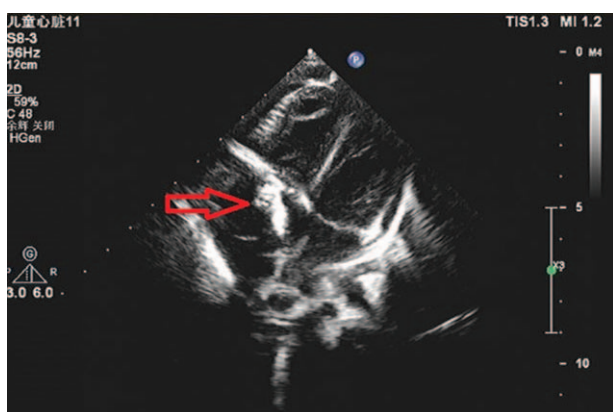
Echocardiography revealed an extensive calcification cardiac mass extending from the inferior vena cava across the right atrium and tricuspid valve into the right ventricle.
